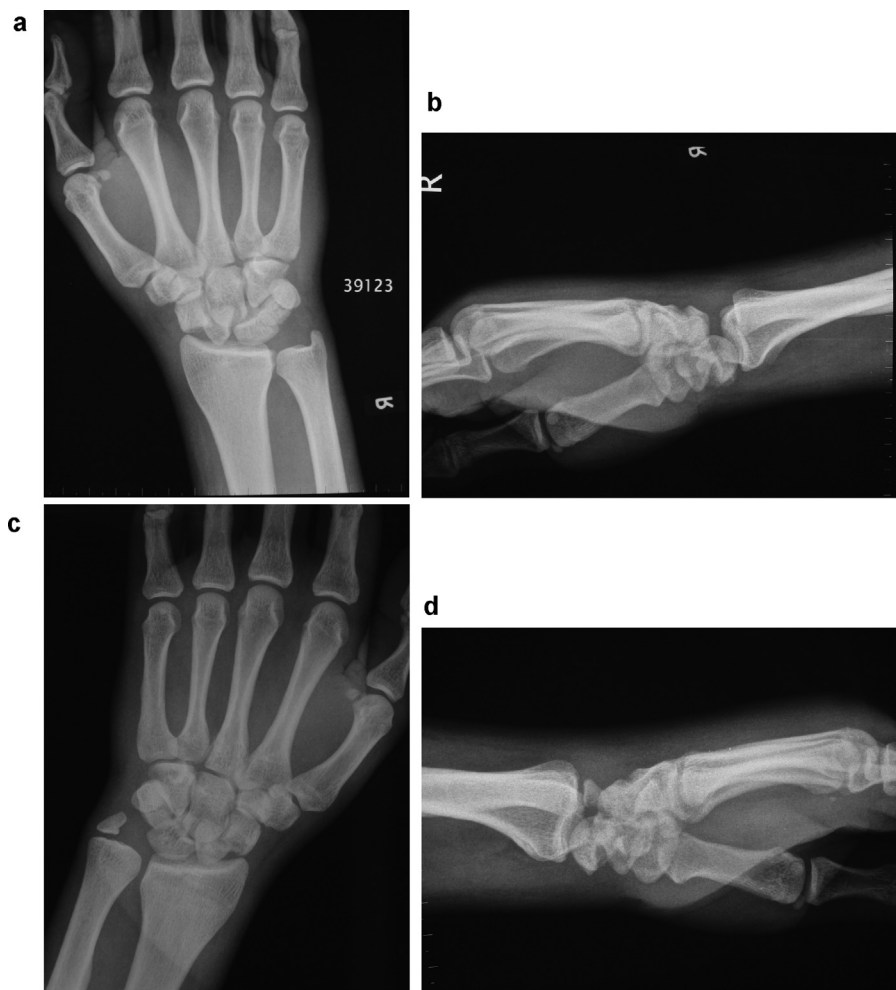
Right wrist. (a) Anteroposterior and (b) lateral radiographs showing dorsal trans-scaphoid perilunate fracture–dislocation. The fracture through the waist of the scaphoid is clearly seen. Left wrist. (c) Anteroposterior and (d) lateral radiographs showing the same appearance as (a) and (b). Old avulsion fracture of the ulnar styloid was prior to this injury.
